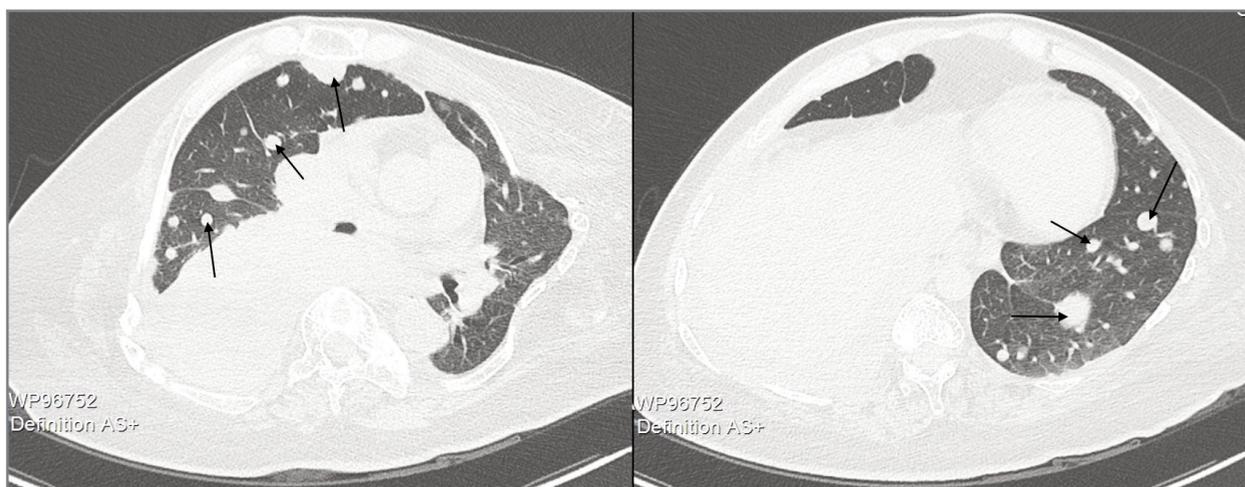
Left - One year post-operative thoracic CT scan showing metastatic lesions affecting the right lung. Right - One year post-operative thoracic CT scan showing severe metastatic lesions affecting the left lung
